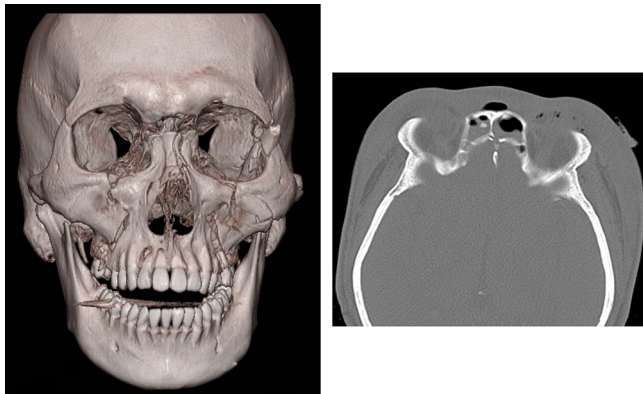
Facial bone three-dimensional computed tomographic scan (left) and an axial view showing the nasofrontal duct injury and the frontal sinus fracture (right).
